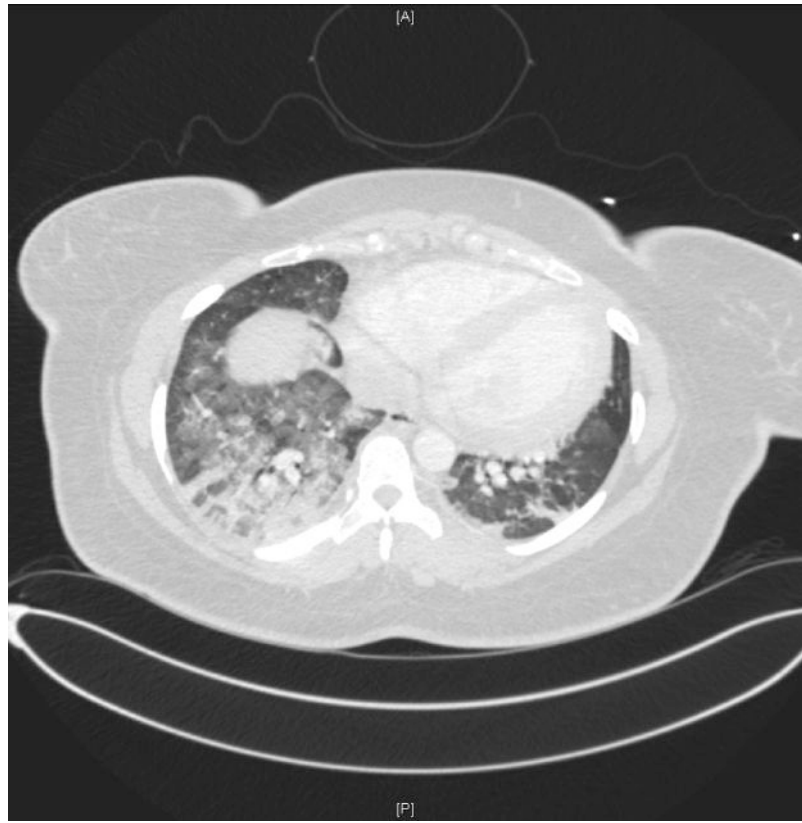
Axial CT scan from a patient with acute respiratory distress syndrome (ARDS) caused by trauma and aspiration pneumonia. Prominent dorsal opacities are visible with progressive ventral to dorsal increase in CT density. Frontal lung regions are better aerated.
